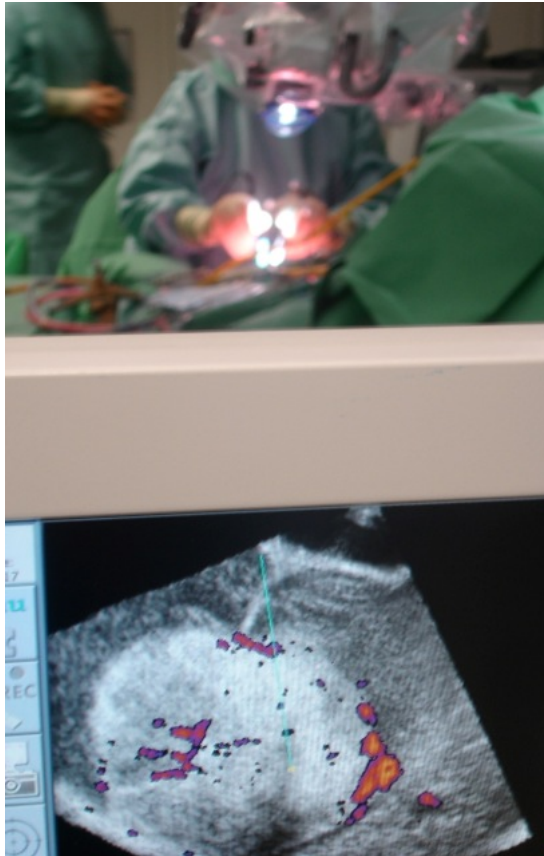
Surgeons in the operating room using ultrasound to guide surgery. The ultrasound image shows a tumor and the blue line is an example of the surgeon using the pointer tool to locate a structure in the brain.
